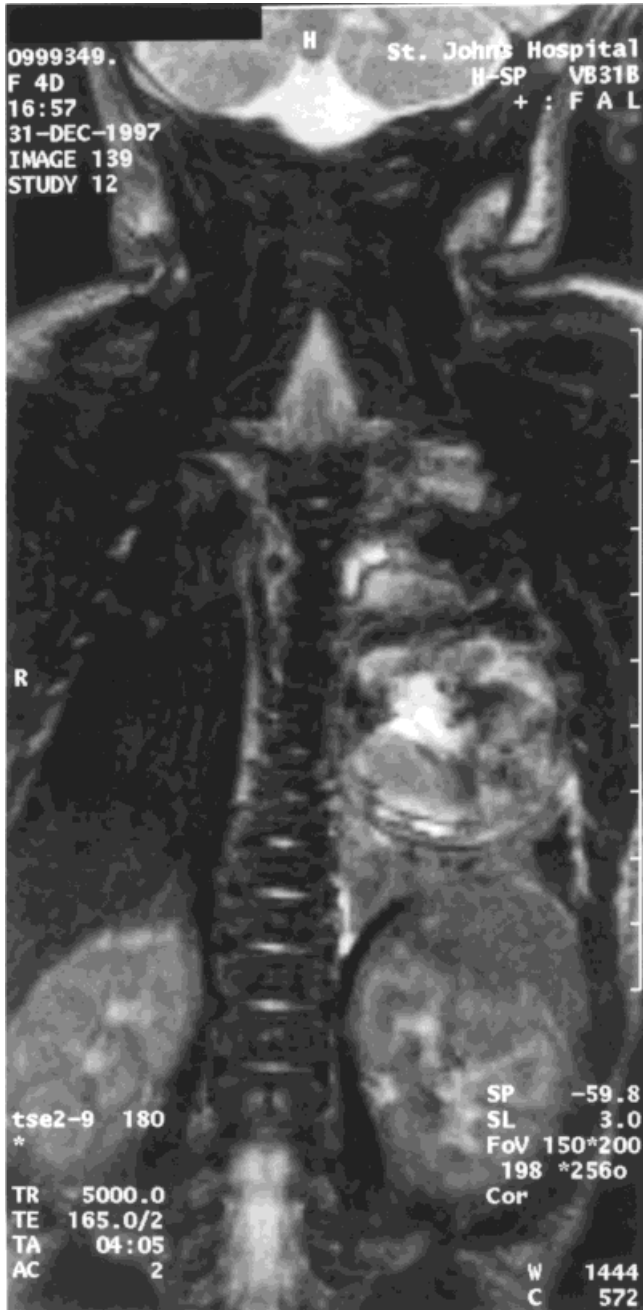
Abdominal computed tomography scan showing left chest wall hamartoma in infant who later demonstrated left hemihypertrophy.
